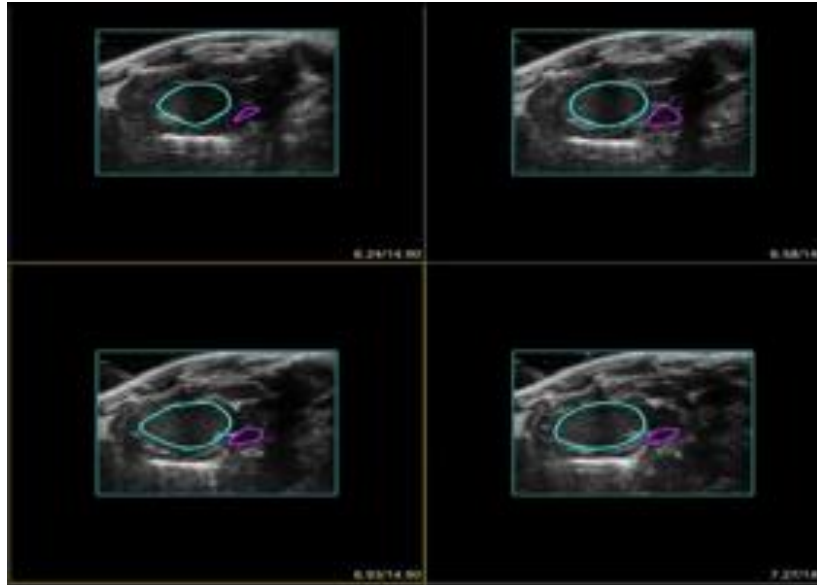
Slice view of the three-dimensional echocardiography (original work)
